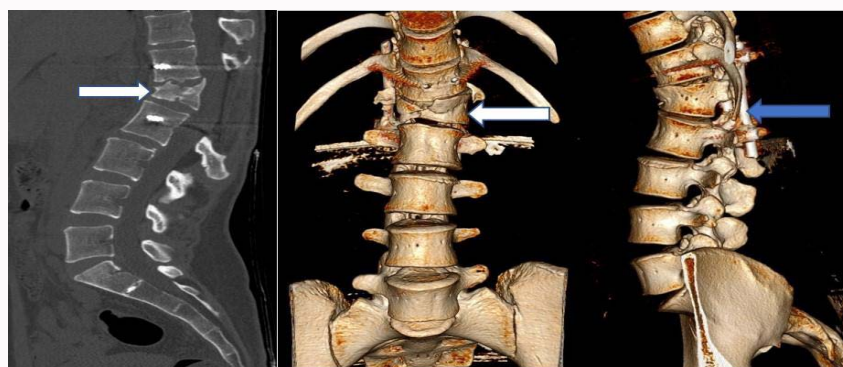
Preoperative sagittal CT and 3D reconstruction showing the fracture and associated kyphotic deformity (white arrows). The posterior transpedicular fixation is seen intact (blue arrow).
